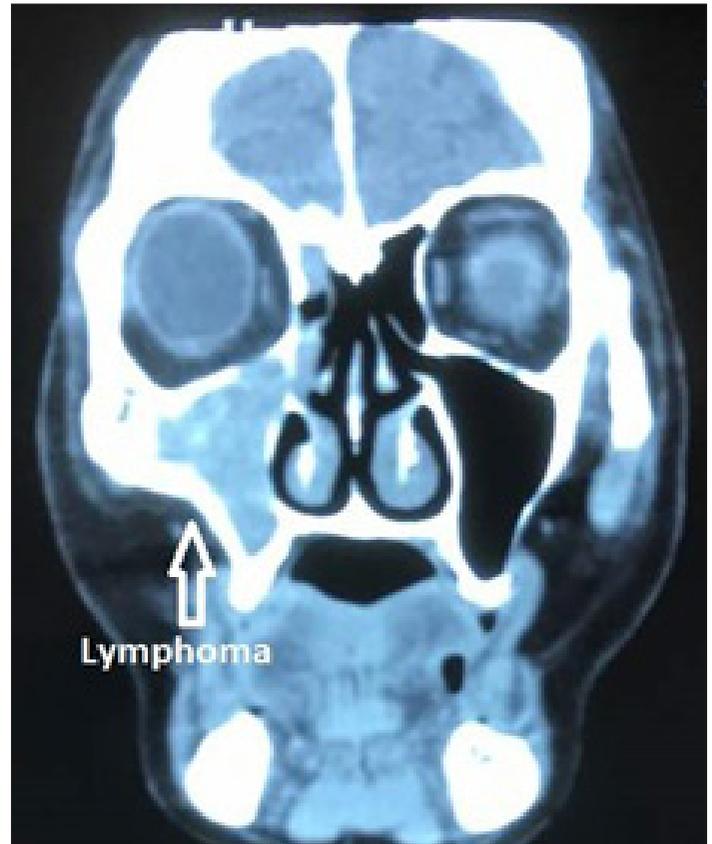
CT coronal skull with right maxillary sinus mass
